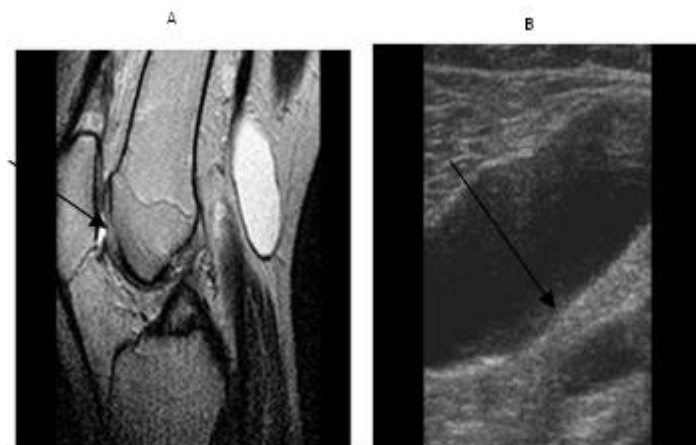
Knee joint, Arthrosynovial cyst, coronal T2 weighted Magnetic Resonance Imaging (MRI):A, longitudinal view Ultrasound: B
